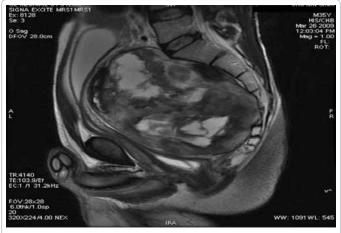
Magnetic resonance imaging showing a well-defined soft-tissue mass measuring $24 \times 17 \times 9.0$ cm located in the retrorectal space.
